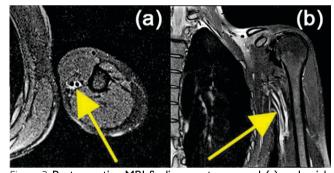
Postoperative MRI findings on transversal (a) and axial (b) slices. Yellow arrows depict previous tumor site.
